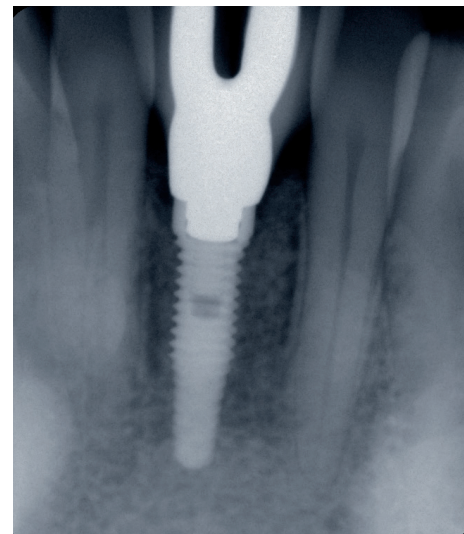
Radiographic image of the "in-between" implant. Note the implant's appropriate distance from the adjacent natural teeth roots.
